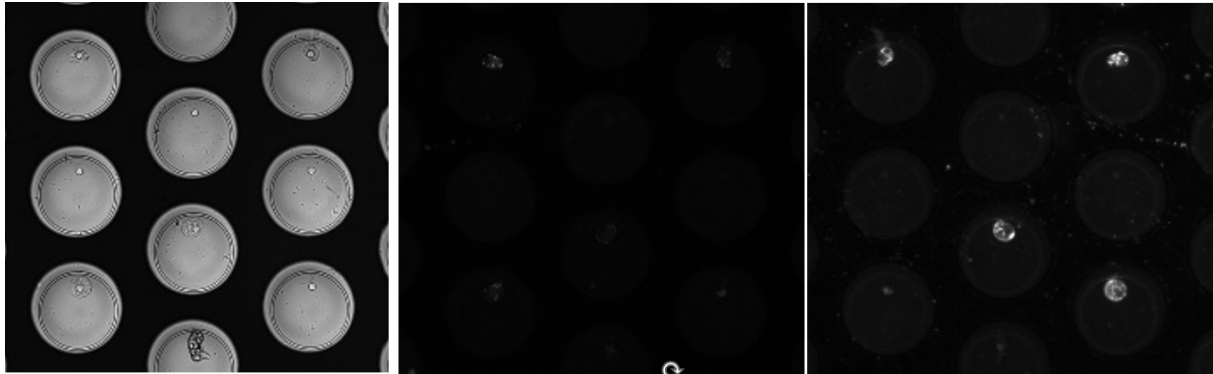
LNCaP cells seeded in a chip. Left: brightfield. Middle: APC (CD45). Right: PE (PSMA).
